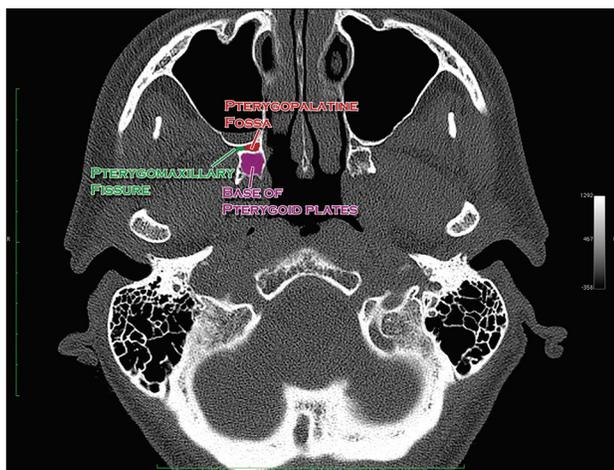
CT scan (bone window) axial section through the lower portion of the pterygopalatine fossa
